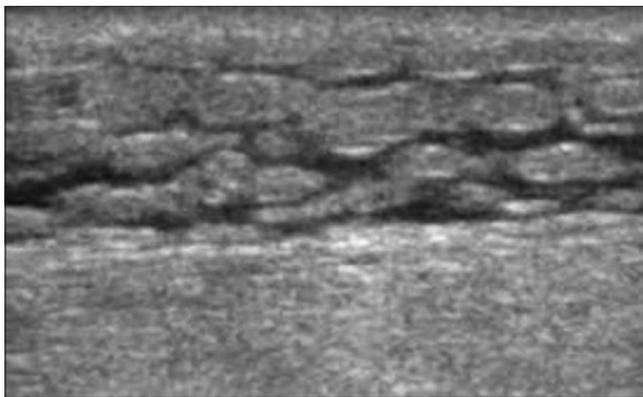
Ultrasound image of the subcutaneous fat demonstrating the “cobble appearance” of edematous fat. The fluid is interdigitating between the fat globules. Septic versus aseptic fluid cannot be distinguished on imaging.
